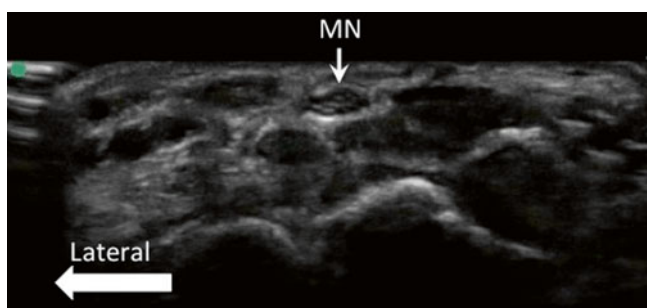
Same scan as Fig. 35.5. The ultrasound probe is tilted. With this maneuver, the tendons “disappear” while the median nerve (MN) remains because tendons in general are more anisotropic than the nerves (Reproduced with permission from Philip Peng Educational Series)
